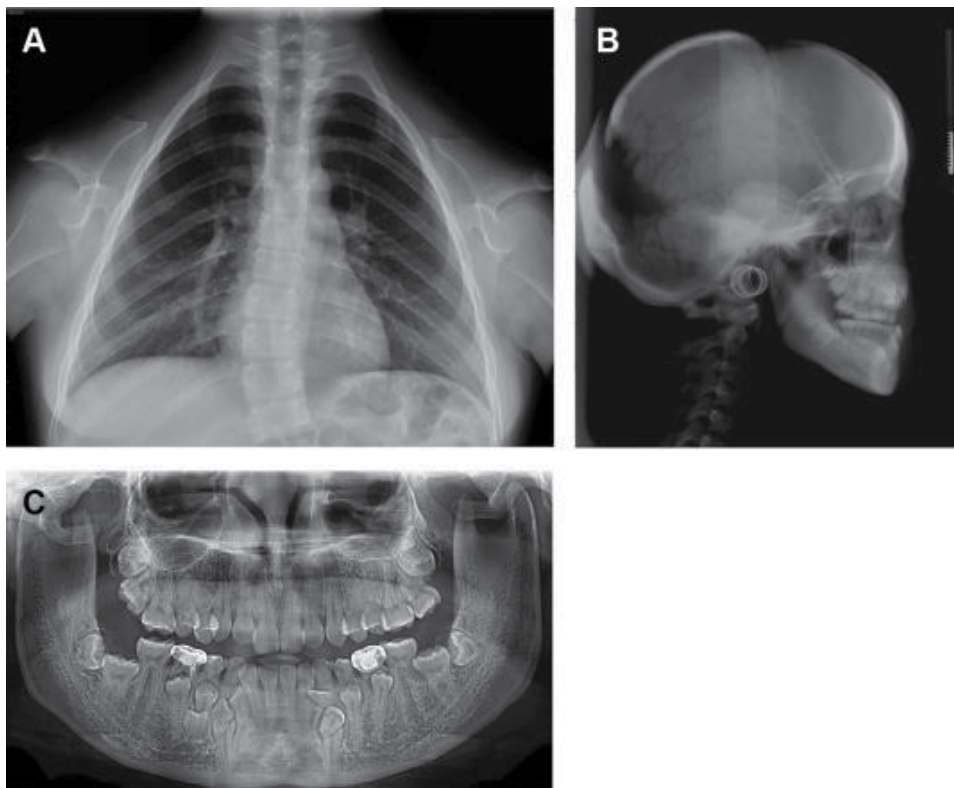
Chest radiograph, lateral skull view radiograph and DPT showing, absence of clavicle, bossing of the cranial bones and multiple unerupted supernumerary teeth respectively in a patient with cleidocranial dysostosis.*
